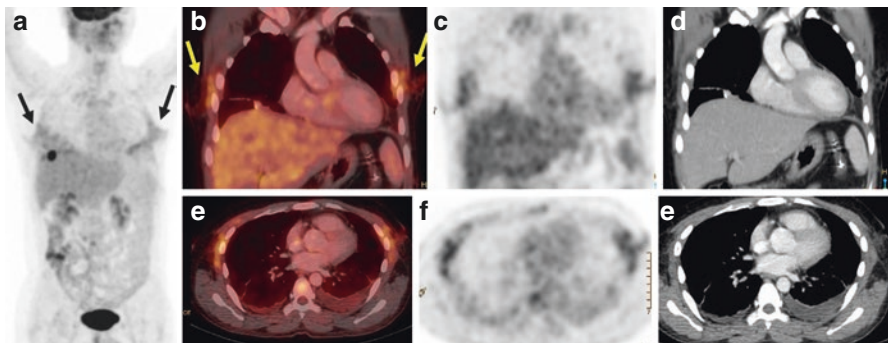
MIP (a), coronal (b–d), and axial (e–g) images of whole-body FDG PET/CT scan of a 40-year-old male with adenocarcinoma rectum, who had undergone metastatectomy for bilateral lung nodules 4 months prior to the PET scan. Low-grade diffuse FDG uptake is noted at the site of thoracotomy incision in bilateral anterolateral chest wall (arrows)
